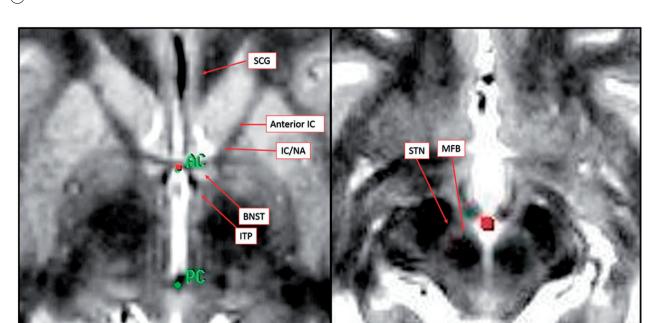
Common targets for DBS in psychiatric disorders. To the right is a transaxial MRI 4 mm below the anterior commissure (AC) and posterior commissure (PC) in the third ventricle. The subthalamic nucleus (STN) and the medial forebrain bundle (MFB) are marked. The area within the red rectangle is seen magnified on the left, 4 mm higher on the AC-PC level. Targets marked here are the subcallosal gyrus (SCG), internal capsule (IC), the nucleus accumbens (NA), bed nucleus of stria terminalis (BNST) and the inferior thalamic peduncle (ITP).
